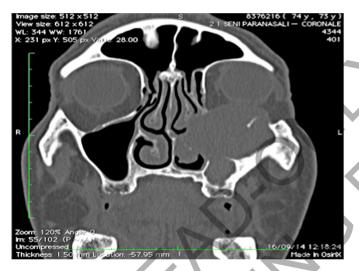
A coronal CT scan of a left maxillary mucocele eroding orbital floor and medial maxillary sinus wall.
